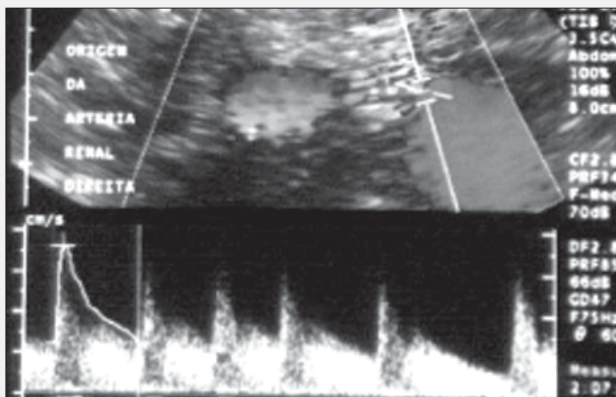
Example of hemodynamically significant stenosis of the left renal artery on vascular color Doppler ultrasound. Note the flow turbulence in the renal artery and the increase in systolic velocity (400 cm/s).
